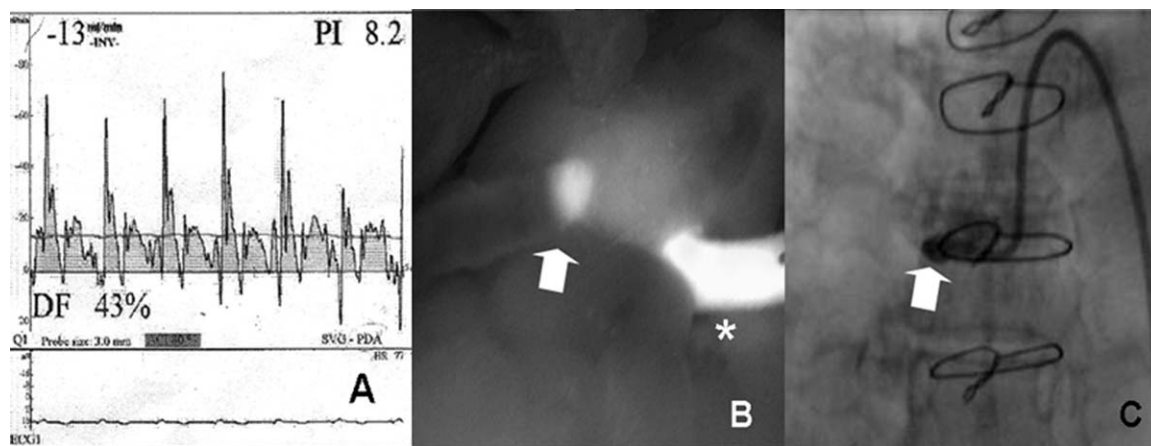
Representative TTF assessment (A), ICG angiogram (B), and x-ray angiogram (C) images of an occluded saphenous vein graft to the posterior descending coronary artery. TTF measurements were grossly abnormal (pulsatility index > 5 and diastolic flow fraction 43%). ICG angiography and x-ray angiography show an occluded vein stump (white arrows). A normally filling proximal vein graft to an obtuse marginal branch is seen in the ICG angiogram (asterisk). TTF, transit-time ultrasound flow; ICG, indocyanine green.
